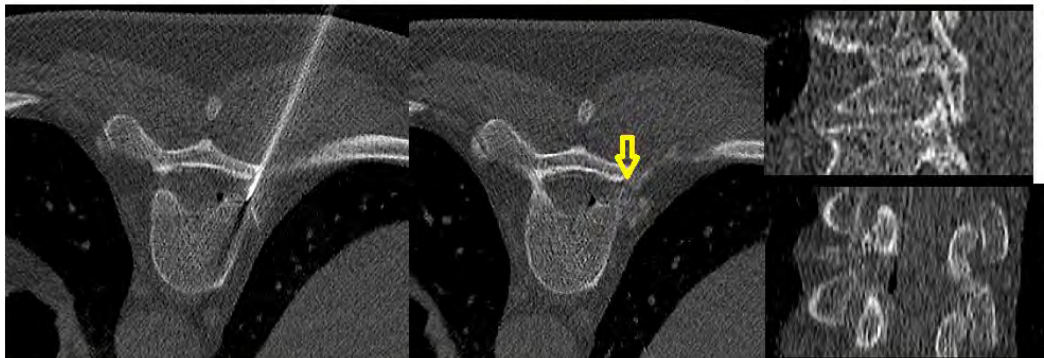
Images from CT-guided fibrin glue injection targeted at the T8-T9 right nerve root sheath demonstrate fibrin glue material mixed with contrast filling the nerve sheath. Single needle technique was used.
